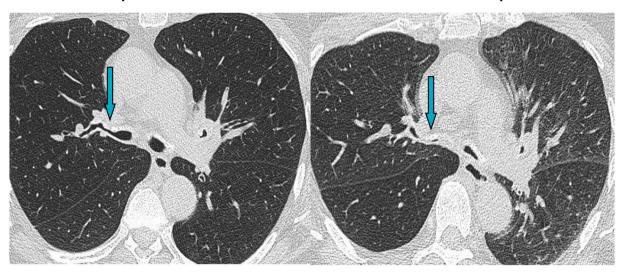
A dynamic airway collapse seen on high resolution chest CT scan.
